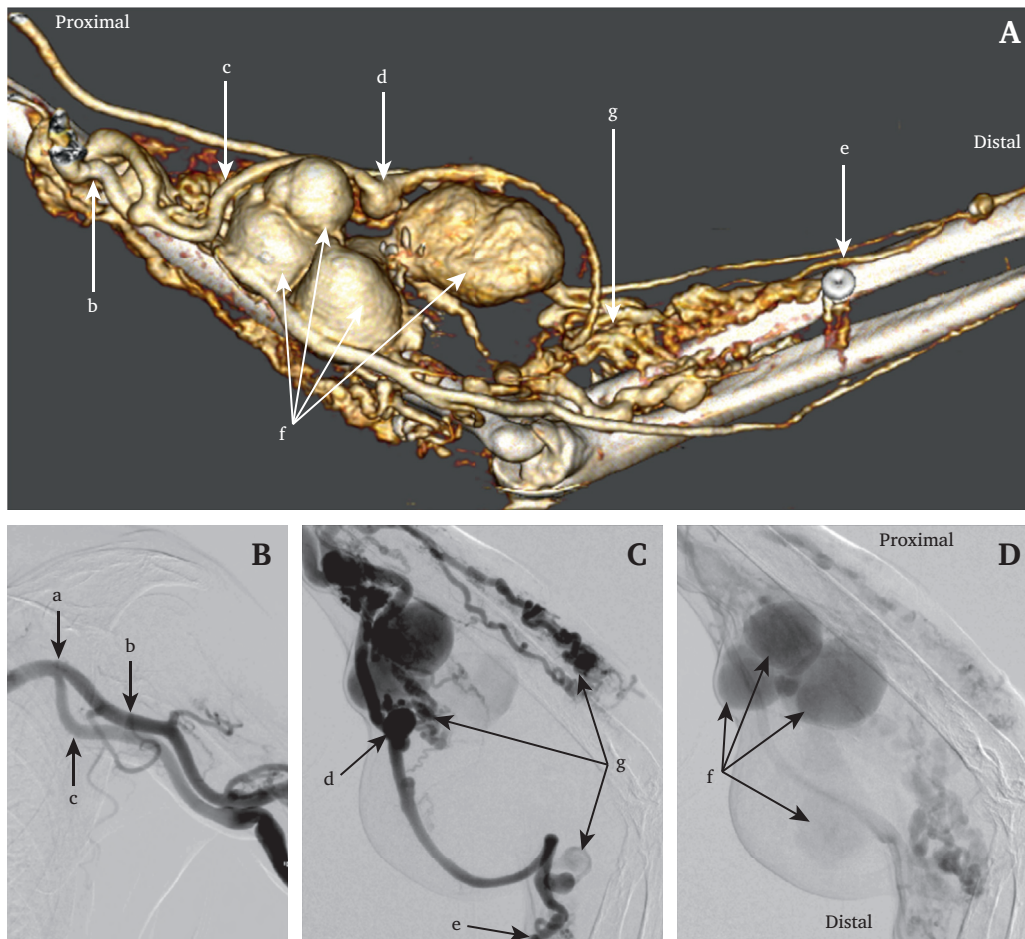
(A) Computed tomography angiography individualising five aneurysmal formations at the portal venous phase. (B) Left subclavian arteriography showing duplication of the brachial network at axillary level. (C) Arteriography of the brachial artery presenting an aneurysm at the level of the elbow with multiple AVMs. (D) Phlebography showing four venous aneurysms, the largest aneurysm was less visible due to the presence of thrombus. (a) brachial artery bifurcation, (b) deep brachial artery, (c) brachial artery, (d) brachial artery aneurysm; (e) radial artery, (f) venous aneurysms, (g) AVM with nidus and dilated outflow veins.
